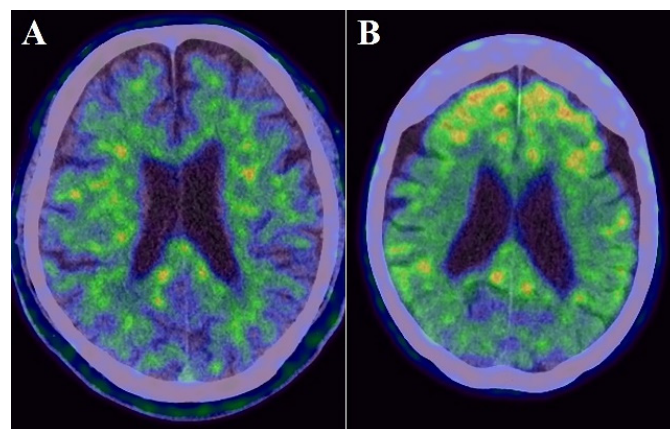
Examples images of an individual with lower PiB uptake ((A): cortical SUVR value = 0.804) and with higher PiB uptake ((B): cortical SUVR value = 2.584).
